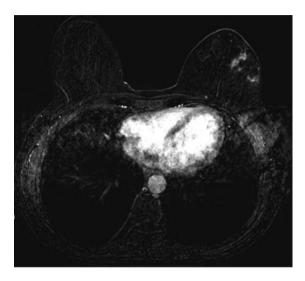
Contrast-enhancement magnetic resonance imaging showing multiple enhancing nodules, some of them confluent, with blurred margins and maximum diameter of about 1 cm in the left breast.
